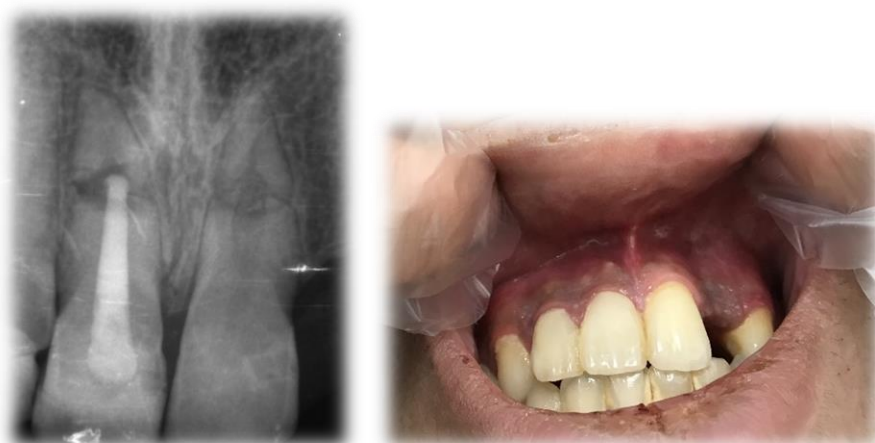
1 year clinical and radiographic follow-up.
